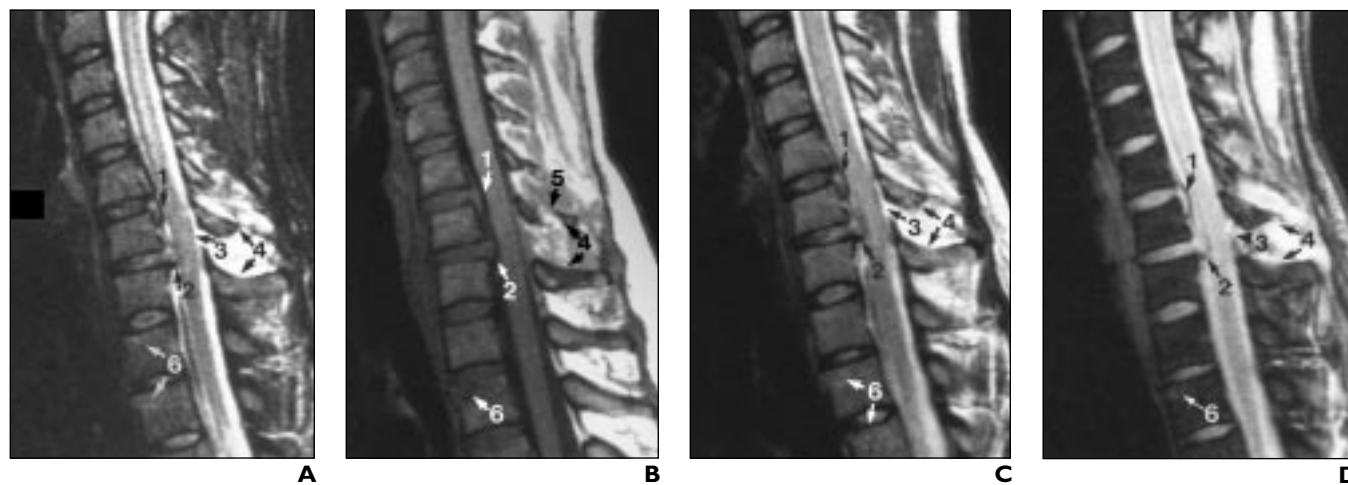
35-year old woman involved in head-on motor vehicle collision who presented with severe neck pain, right arm pain, and numbness. Radiographs and CT scans (not shown) showed negative findings. Four pulse sequences from a 1.0-T MR scanner at midsagittal level are provided to allow reader to compare and contrast abnormalities. Findings include disk extrusion and inferior stripping of posterior longitudinal ligament at C5-6 (1); disk extrusion and tear of posterior longitudinal ligament and annulus fibrosus at C6-7 (2); flaval ligament tear at C6-7 (3); splaying of dorsal spines and interspinous ligament tear at C6-7 (4); fracture of C6 spinous process (5); and mild superior endplate impaction fractures of T1, T2, and T3 vertebral bodies (6). Solely on basis of results of MR images, the following day patient was started in traction and taken to surgery where anterior discectomy and fusion at C5-6 and C6-7 were performed. Patient experienced immediate marked improvement in symptoms after surgery.
